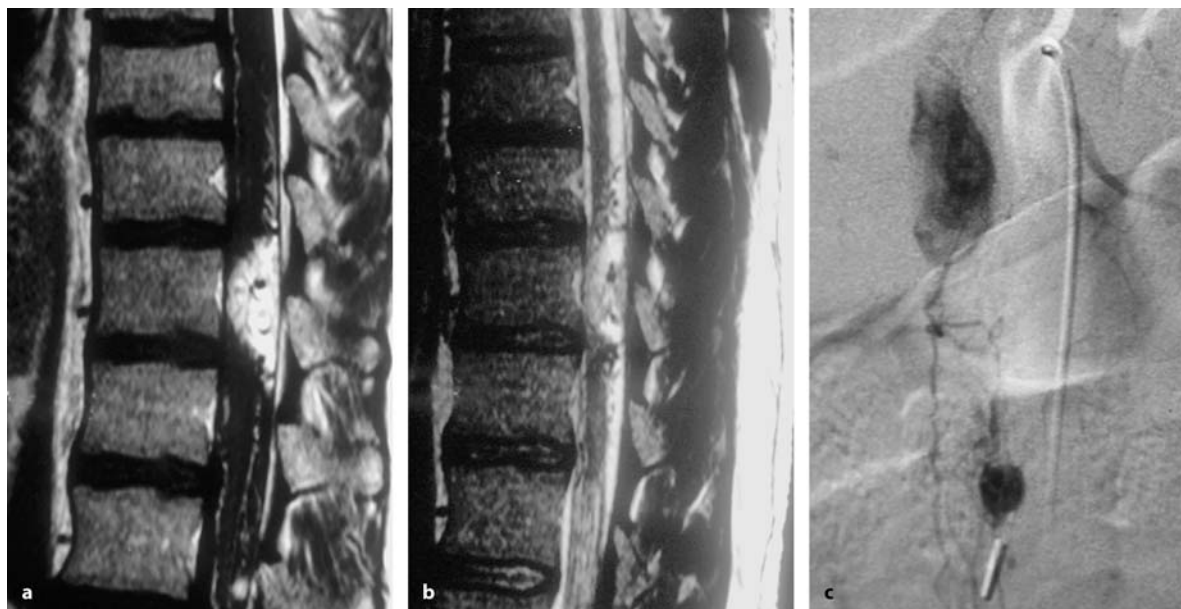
Sagittal T1-weighted MRI scans without (a) and with contrast (b), and T2-weighted images (c) of a meningioma at L1–L2 in a 63-year-old woman. The association with engorged and dilated vessels indicates a very vascularized tumor, as proven by spinal angiography (d)
